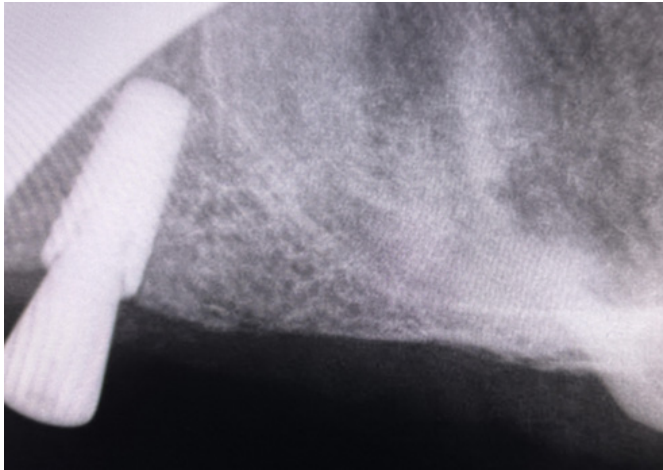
Post-operative periapical imaging of the surgical field
